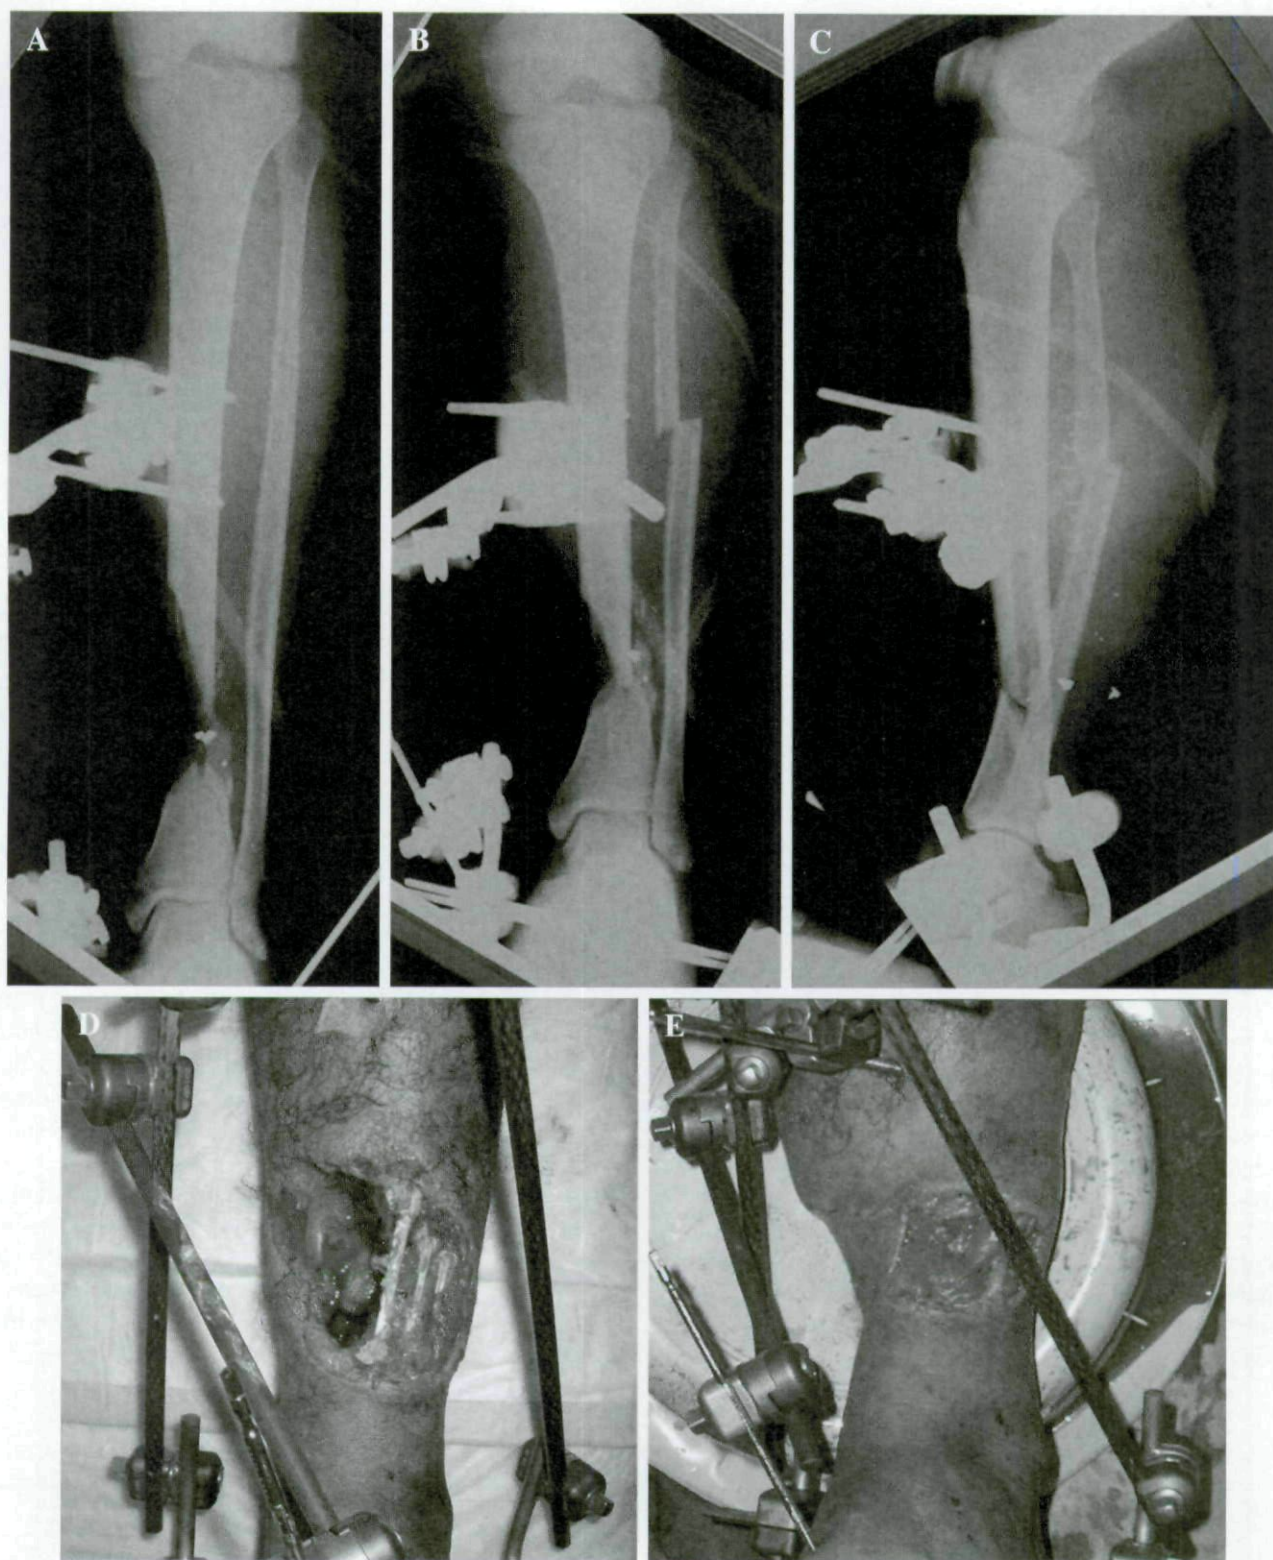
(a–e) Radiographs and photographs of open distal tibia fx before and after acute shortening and angulation. Wound was successfully covered with split thickness skin graft alone.
